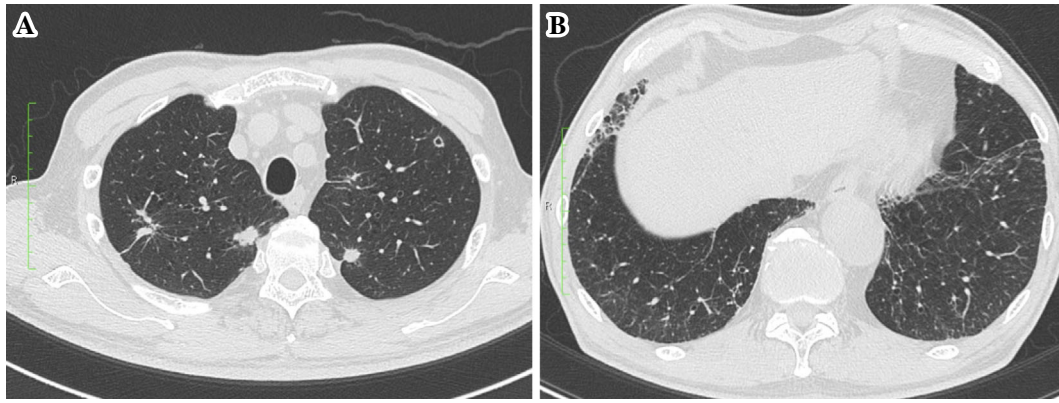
Chest computed tomography from the start of pazopanib therapy. (A) Lung metastases from leiomyosarcoma and (B) pre-existing interstitial lung disease are observed.
